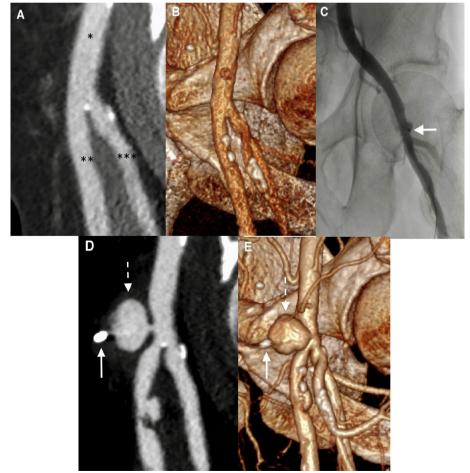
(A,B) CT angiography of left femoral artery pre TAVI. (A) Multiplanar reformat and (B) volume rendering. (C) Angiography after TAVI. Vascular closure with Manta, without any bleeding at the puncture site. Solid arrow indicates steel suture lock well apposed to the arterial wall. (D,E) CT angiography 7 weeks post TAVI. (D) Multiplanar reformat and (E) volume rendering at puncture site. Manta suture lock (solid arrow) anterior to the pseudoaneurysm (stapled arrow). * Indicates common femoral artery,  superficial femoral artery, and * deep femoral artery. The same anatomical region is displayed in (B)–(D).
